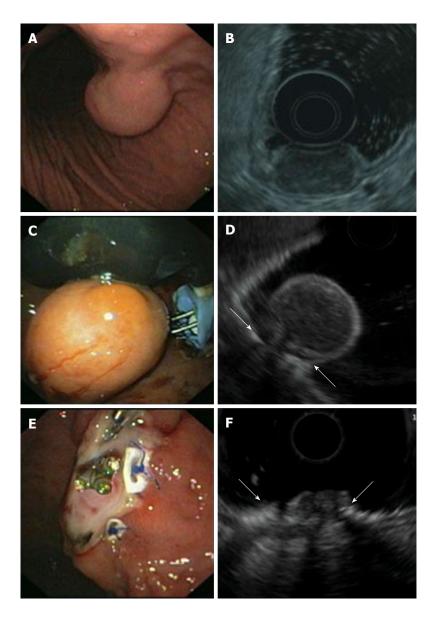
Endoscopic full thickness resection of gastric gastrointestinal stromal tumors after transmural suturing. A: Subepithelial tumor in the gastric corpus; B: Endoscopic ultrasound (EUS) showed a hypoechoic tumor originating from the muscularis propria with a maximum diameter of 27 mm; C: Two transmural sutures underneath the tumor were applied using the Plicator[™] suturing device; D: EUS image of the pseudopolyp after suturing. Arrows are indicating the sutures; E: The tumor was resected with a snare above the sutures. The transmural PTFE-pledgeted sutures are securing gastric wall patency. Resection was macroscopically complete; F: EUS image of the resection site. Arrows are indicating the sutures. There was no evidence of residual tumor.
